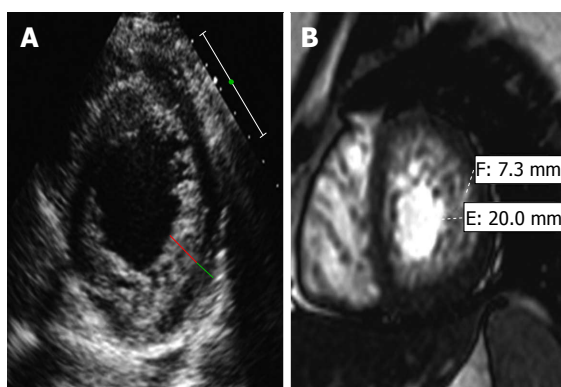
Non-compaction cardiomyopathy in two patients^[105]. A: Dilated cardiomyopathy in a 60-year-old man with new-onset congestive heart failure. Short-axis echocardiogram obtained in systole at the level of the left ventricle (LV) shows a two-layered myocardium with a noncompacted (red line) and compacted (green line) layer along the lateral, inferior, and anterior walls and a maximal end-systolic NC: C ratio > 2 ; B: Symptoms of New York Heart Association Class III heart failure and severely reduced ($\leq 35\%$) LV ejection fraction in a 35-year-old woman. Short-axis 2D SSFP cardiac magnetic resonance imaging obtained in end diastole shows thickening of the LV myocardium, with an NC: C ratio of 2.9. The patient underwent subsequent implantable cardioverter-defibrillator placement for primary prevention of sudden cardiac death.
